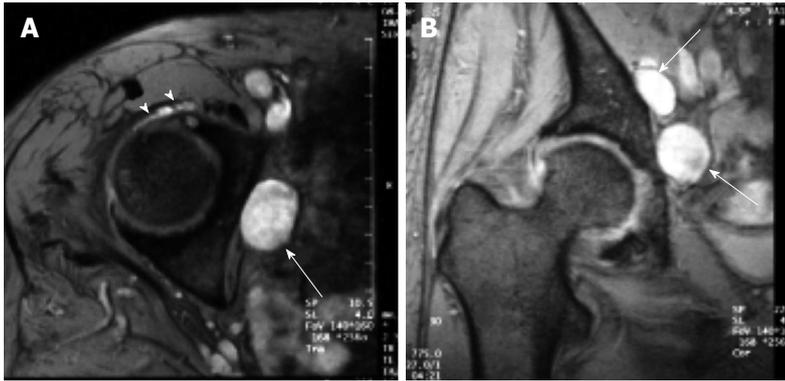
A 75-year-old female with obturator neuropathy. Axial (A) and coronal (B) short tau inversion recovery magnetic resonance images show that the location of the cystic masses (arrows) is consistent with the site of obturator nerve (Ref: [26]). The stalk of the cyst was connected to the anterior joint capsule (arrowheads).
